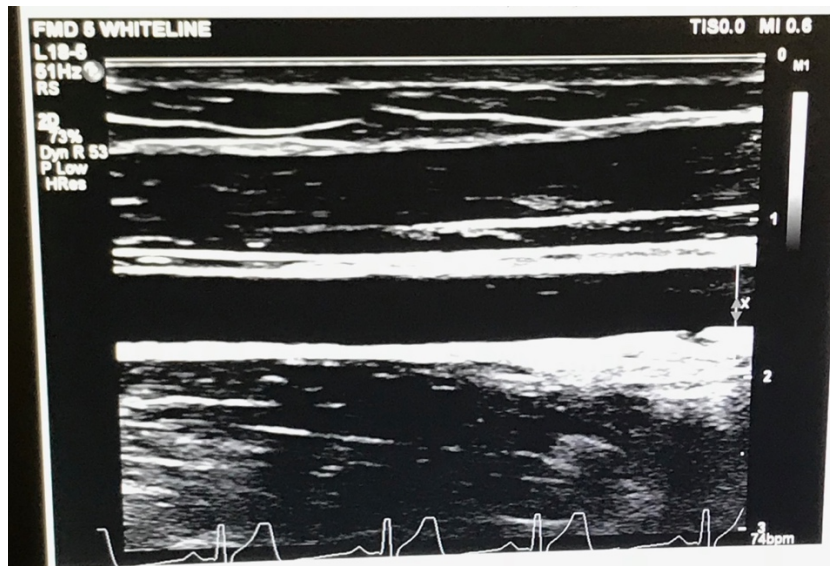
The brachial artery at rest by ultrasound technique.
